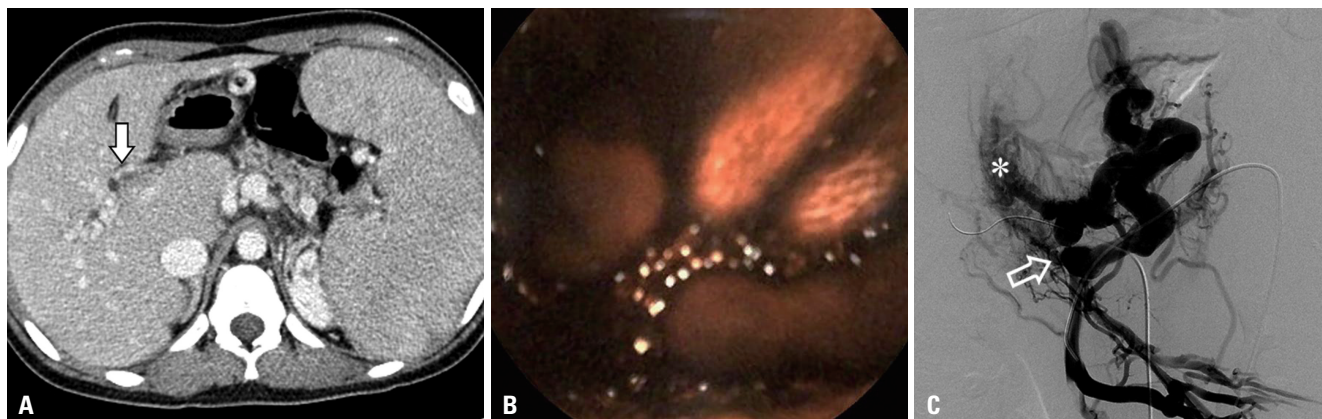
Portal phase of preoperative contrast-enhanced CT image (A) shows total occlusion of portal vein due to extensive thrombosis (arrow) and cavernous malformation of intrahepatic portal veins with splenomegaly. Capsule endoscopy (B) revealed active bleeding and a large amount of blood clots at proximal jejunum. SMV angiography (C) shows cavernous transformation of intrahepatic portal vein (asterisk), and collateral vessels are seen. Total obliteration of SMV (open arrow) is noted. SMV, superior mesenteric vein.
